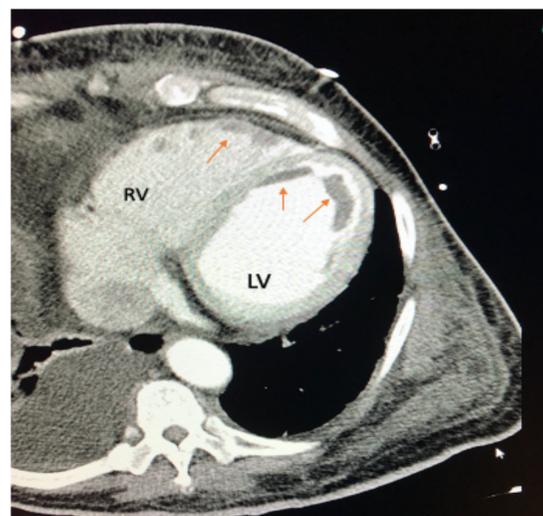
CT Angiogram imaging of the chest showing filling defects along right ventricle (RV) and left ventricle (LV) representing thrombus (arrows)
